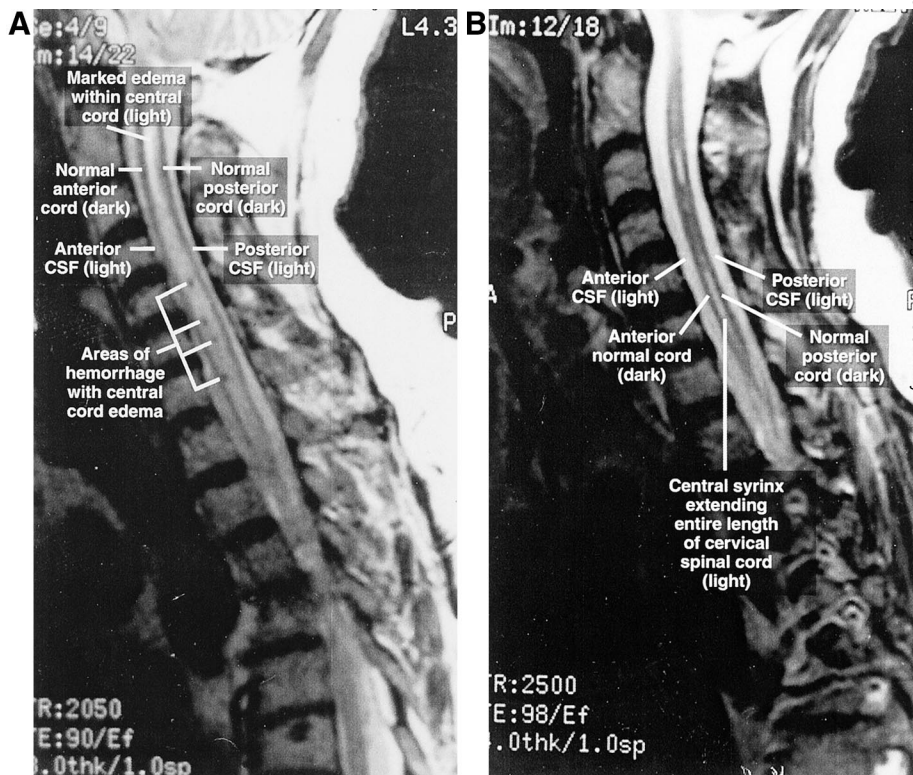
(A) Scan of the T2-weighted saggital section of the cervical spinal cord magnetic resonance imaging performed on post-interscalene block day 7 in patient 3 showing marked edema and hemorrhage throughout the cervical spinal cord. (B) Scan of the T2-weighted saggital section of the cervical spinal cord magnetic resonance image taken 15 months after interscalene block in patient 3, showing a syrinx extending the entire length of the cervical spinal cord. CSF = cerebrospinal fluid.
